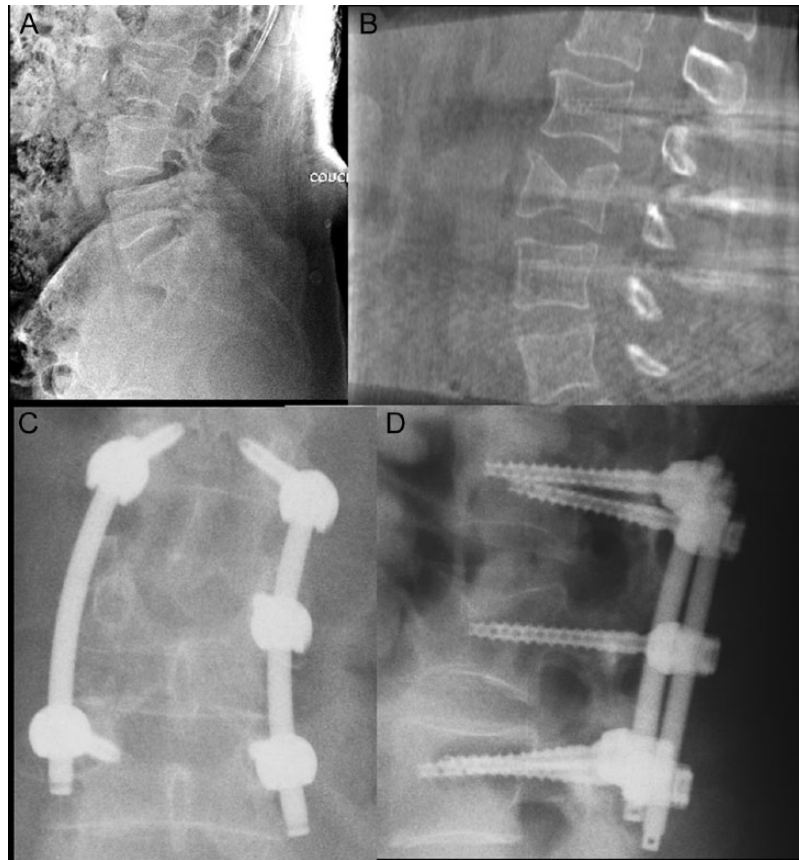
A 55-year-old woman was the victim of a fall from the second floor. Initial X-ray and CT scanner showed A2 L3 fracture (A-B). She was operated with percutaneous fixation with instrumentation of the fractured vertebra in its left pedicle (C-D).
